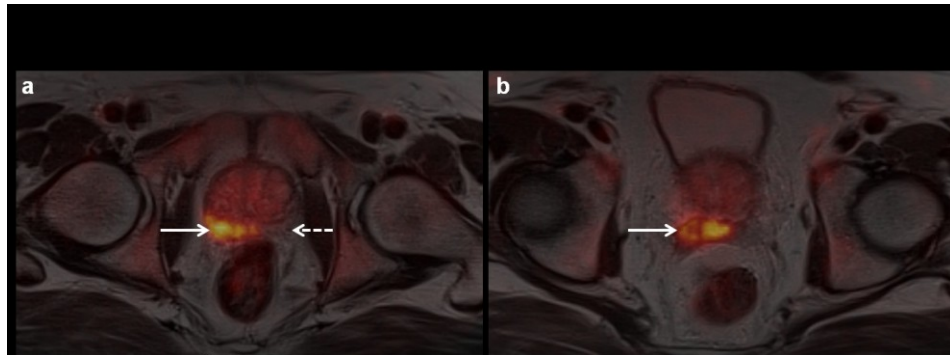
Axial [^{11}C]choline PET (Baseline) fused with T2 weighted axial MRI.
